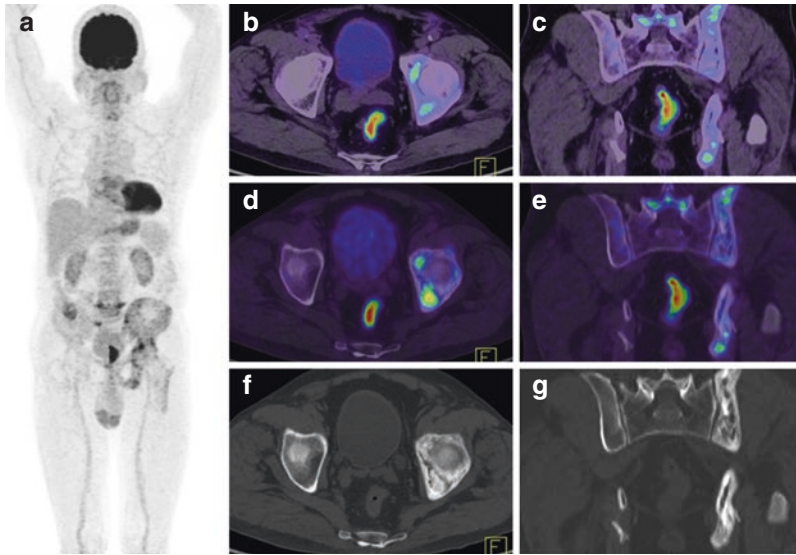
A 68-year-old man with moderately differentiated adenocarcinoma of the rectum, ¹⁸F-FDG PET/CT (a - MIP) for initial staging reveals intensely FDG-concentrating wall thickening in the rectum (b, c) with moderate patchy FDG uptake in diffuse sclerotic lesions (d-g) involving the left hemipelvis and L5 vertebra. Biopsy from left iliac crest revealed it to be a Paget's disease
